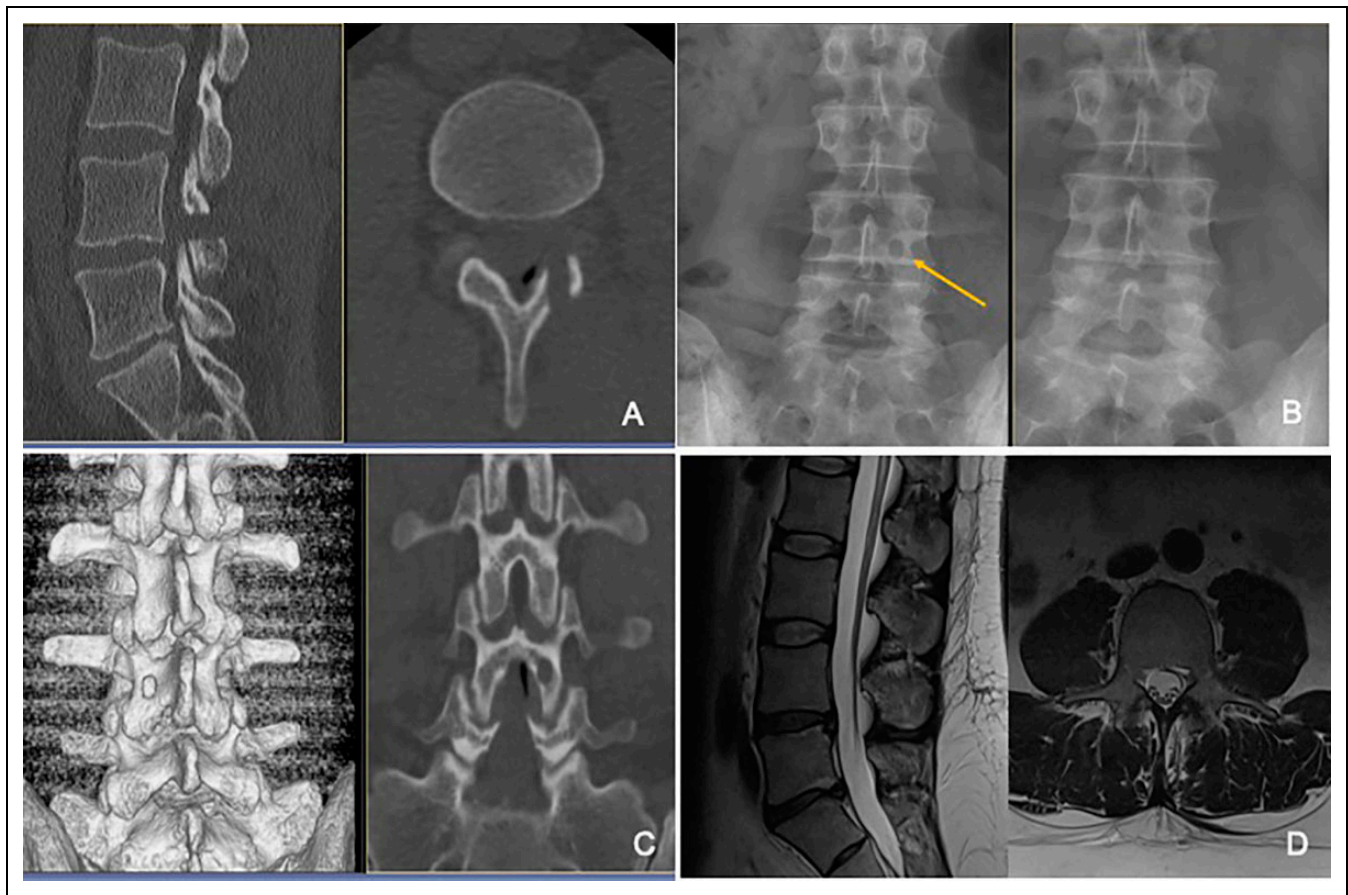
A) Postoperative CT sagittal and axial reconstructions showing the drilled hole in the lamina of L4. B) The pre- and postoperative plain x-ray showing the hole in the lamina on the left image. C) The 3D and coronal reconstruction of the postoperative CT showing clearly the preserved upper and lower border of the lamina and the intact pars interarticularis. D) Postoperative MRI shows the complete removal of the sequestered disc and the minimal muscle trauma.
